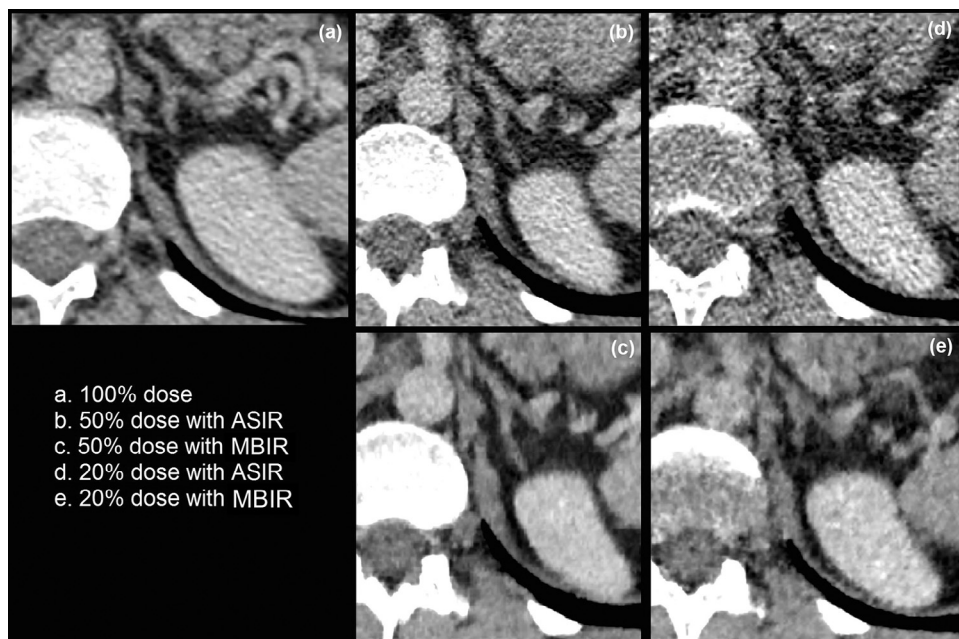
Visibility of the adrenal glands for the 100% dose CT image (a), and two reconstruction algorithms and dose levels (b–e). Note that the contours of the gland are better defined on the MBIR images (c,e) than on the corresponding ASIR images (b,d). ASIR, adaptive statistical iterative reconstruction; MBIR, model-based iterative reconstruction.
